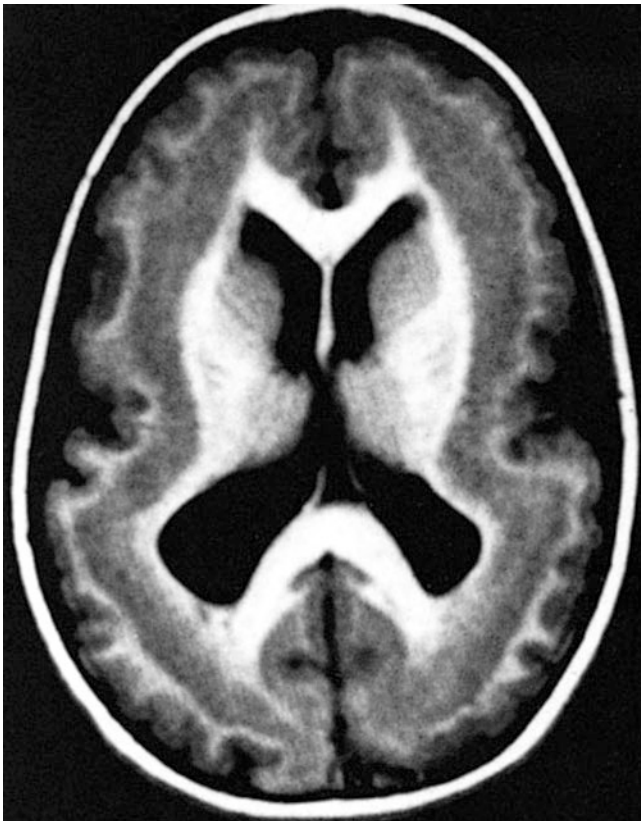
T1-weighted MRI of a double cortex (subcortical band heterotopia)
